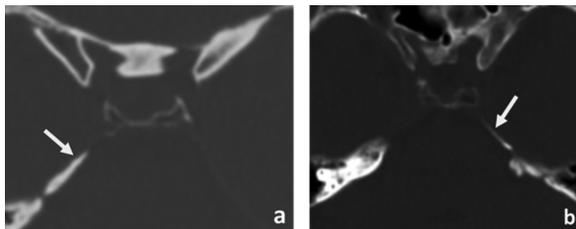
Unilateral partial ossification of petrosphenoid ligament (PSL); A. Axial computed tomography image showing unilateral ossification of PSL on the right side (white arrow) in a 26-year-old female; B. Axial computed tomography image showing unilateral ossification of PSL on the left side in a 59-year-old male (white arrow).
